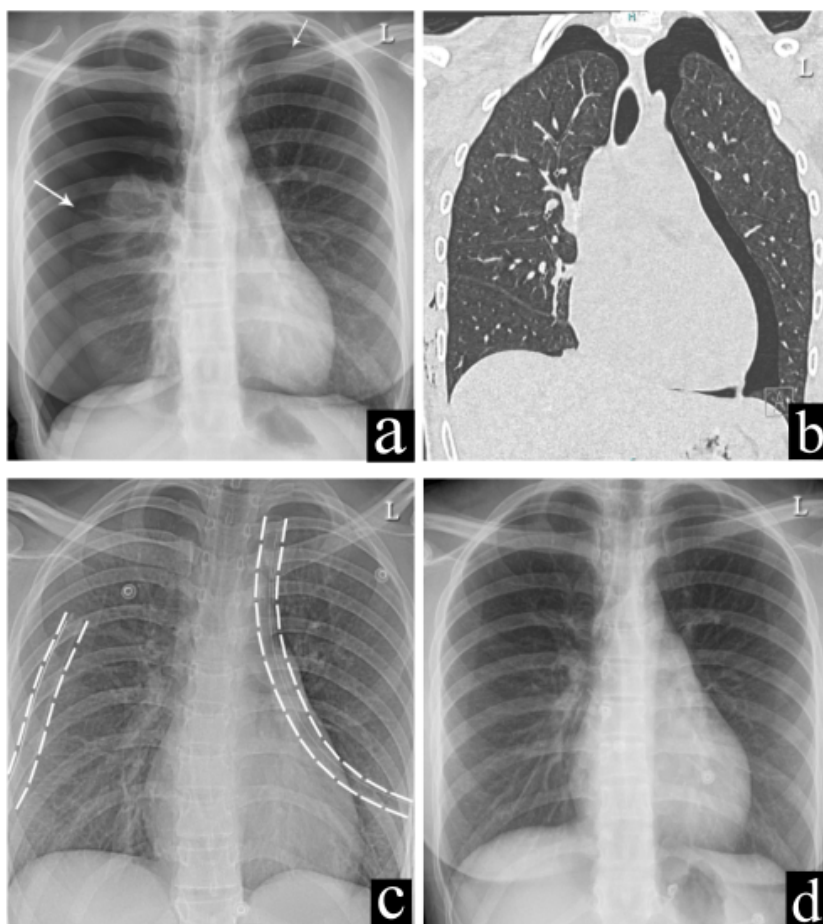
Chest imaging demonstrating bilateral pneumothorax following acupuncture and subsequent recovery. (a). Post-acupuncture chest radiograph showing bilateral visible pleural lines (annotated arrows) and absence of peripheral lung markings, consistent with bilateral pneumothoraces. The right lung is nearly completely collapsed. No diaphragmatic flattening or mediastinal shift is evident. (b). Coronal CT chest image (lung window) demonstrating bilateral pneumothoraces with well-defined visceral pleural lines and air in the pleural spaces. Note iatrogenic subcutaneous emphysema along the right lateral chest wall related to chest tube insertion (chest tube not in field of view). (c) Chest radiograph after bilateral intercostal drain (outlined with dashed lines) insertion showing near-complete resolution of bilateral pneumothoraces with re-expansion of partially collapsed lungs. (d) Follow-up chest radiograph after removal of both intercostal drains demonstrating full re-expansion of both lungs with complete resolution of the pneumothoraces.
